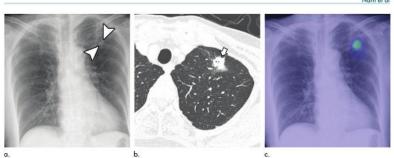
Images in a 78-year-old female patient with a 1.9-cm part-solid nodule at the left upper lobe. (a) The nodule was faintly visible on the chest radiagraph (arrowheads) and was detected by 11 of 18 observers. (b) At contrast-enhanced CT examination, biopsy confirmed lung adenocarcinoma (arrow). (c) DLAD reported the nodule with a confidence level of 2, resulting in its detection by an additional five radialogists and an elevation in its confidence by eight radialogists.
